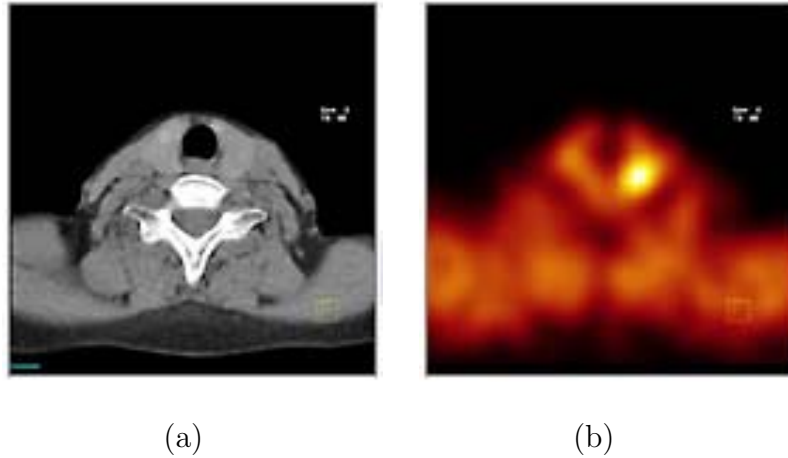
(a) a CT slice showing anatomical detail in a traverse section through the parathyroid, and (b) a slice from a single-photon computed tomography (SPECT) image showing function. The bright spot is a benign tumor.
